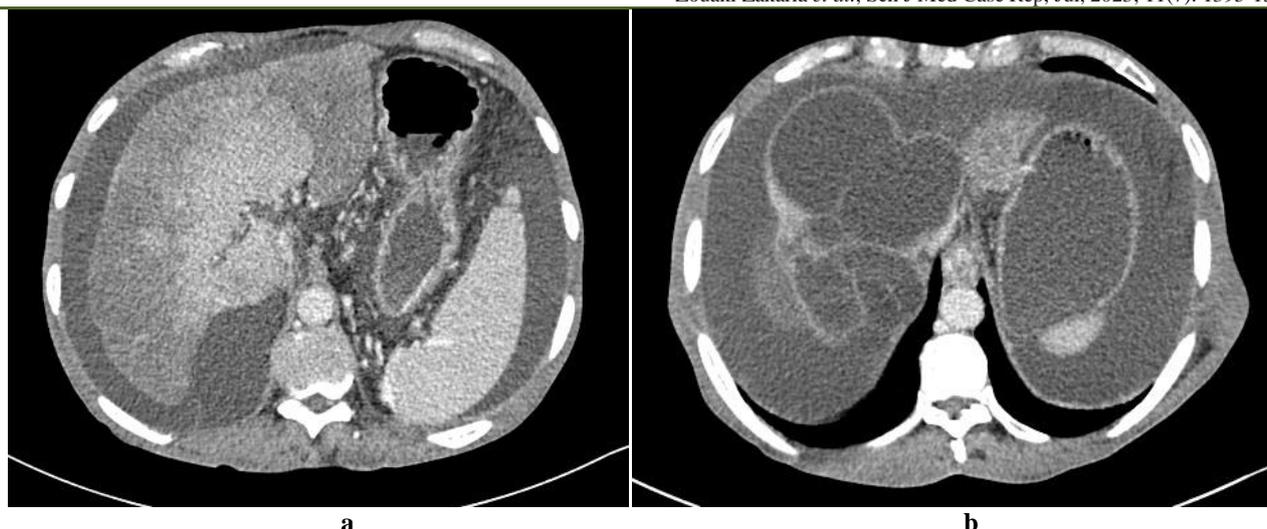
CT scan after portal contrast injection. Large multivesicular hydatid cyst of the hepatic dome compressing the suprahepatic veins and inferior vena cava (a) with a dysmorphic liver with nodular contours, peripheral atrophic liver enhancement defect compared to the center, and abundant ascites (b)
